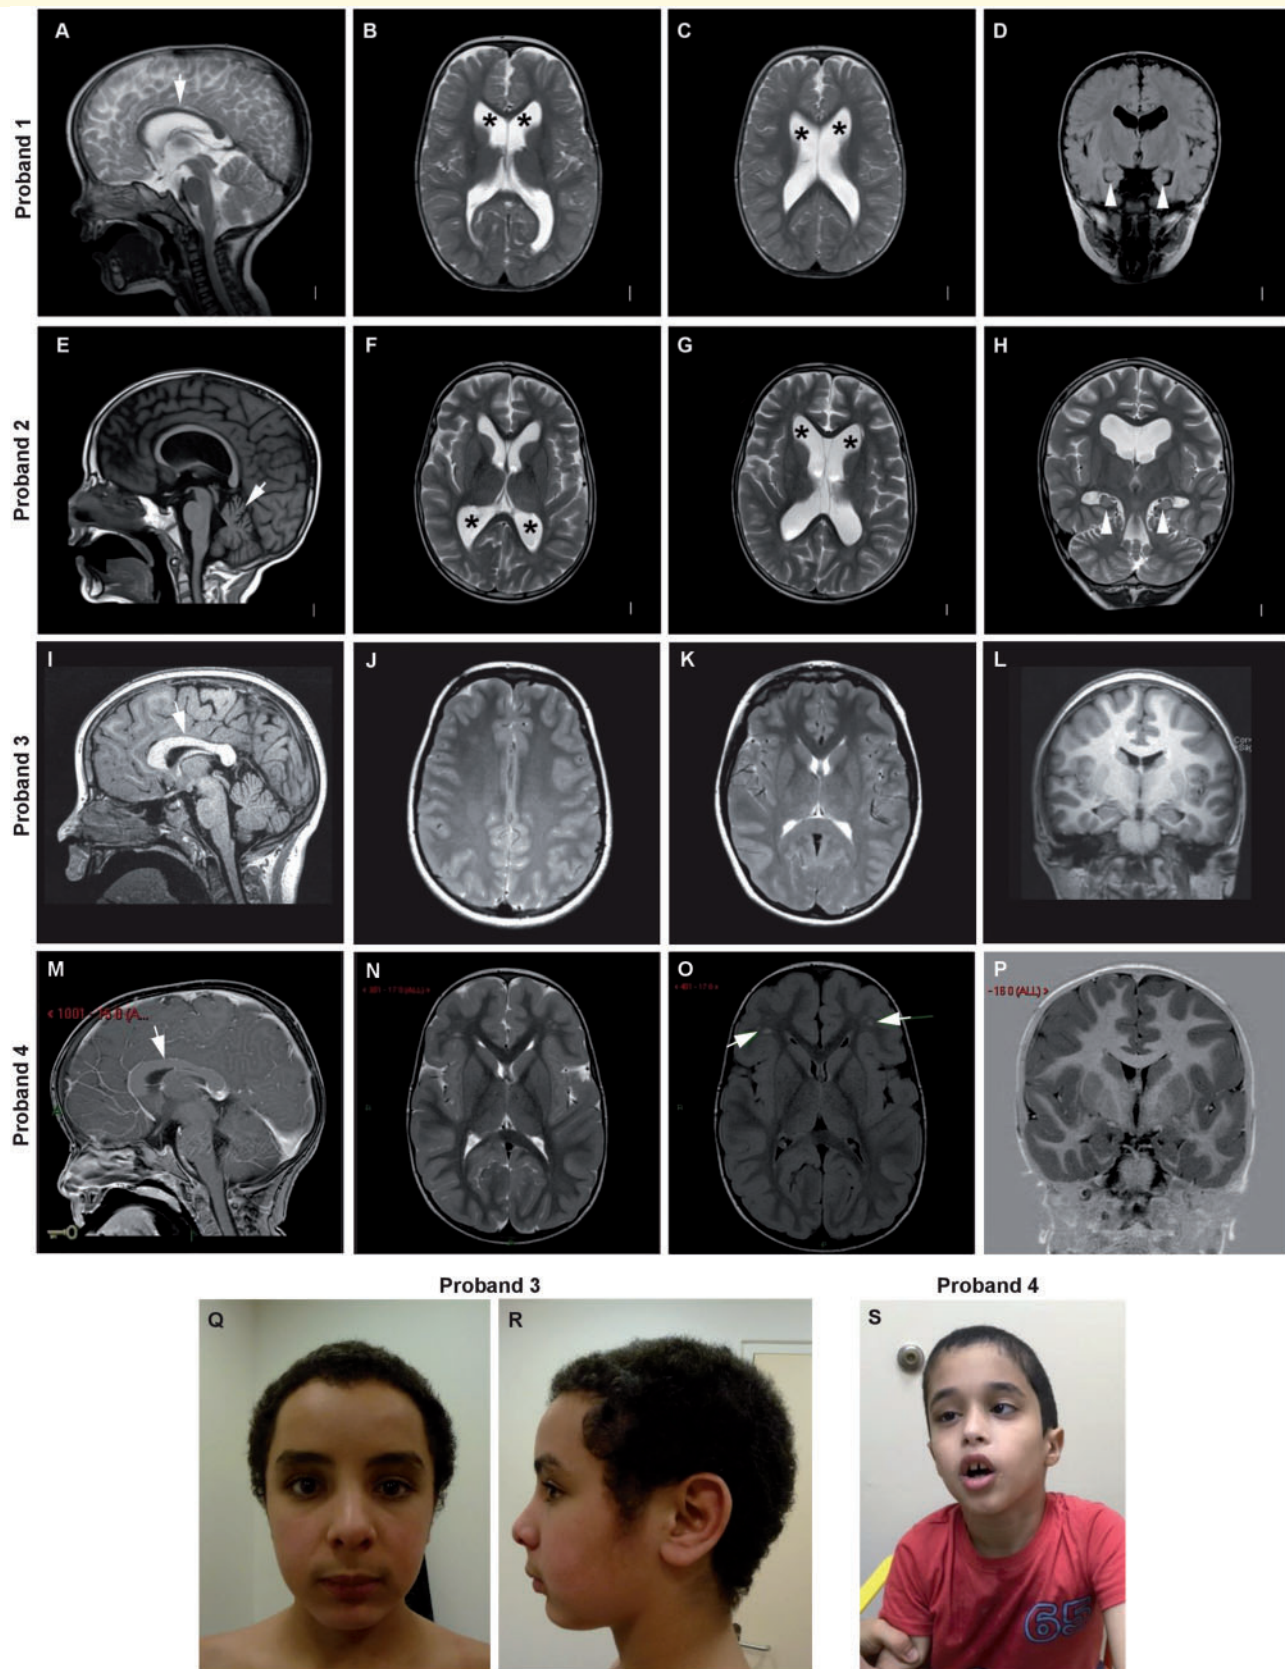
Brain MRI and facial features of individuals with heterozygous *PAK1* mutation. Brain MRIs of Proband 1 at age 2 years (A–D), Proband 2 at age 14 years (E–H), Proband 3 at age 12 years (I–L) and Proband 4 at age 8 years (M–P). Macrocephaly was caused by megalencephaly with or without accompanying ventriculomegaly. (A) T₂ mid-sagittal image showing a thin corpus callosum (arrow). (B and C) T₂ axial images showing ventriculomegaly (asterisks). (D) T₁ coronal image showing globular and mildly amorphous hippocampi bilaterally. (E) T₁
